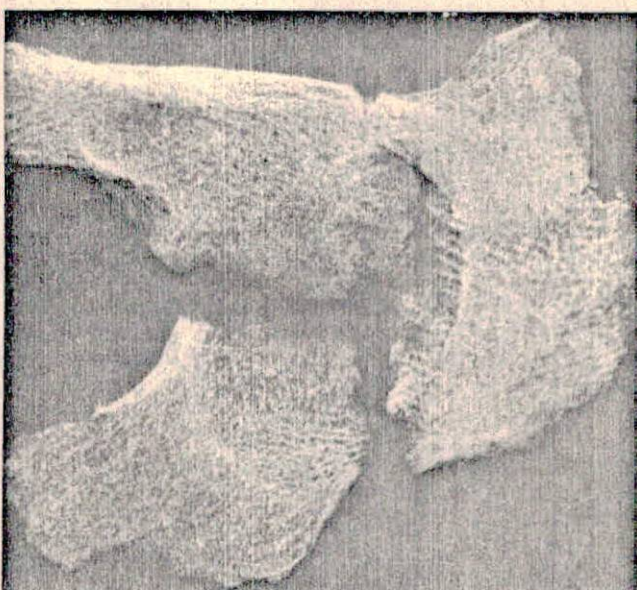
Case 6. Roentgenogram of remnants (arrows) of left acetabulum.
